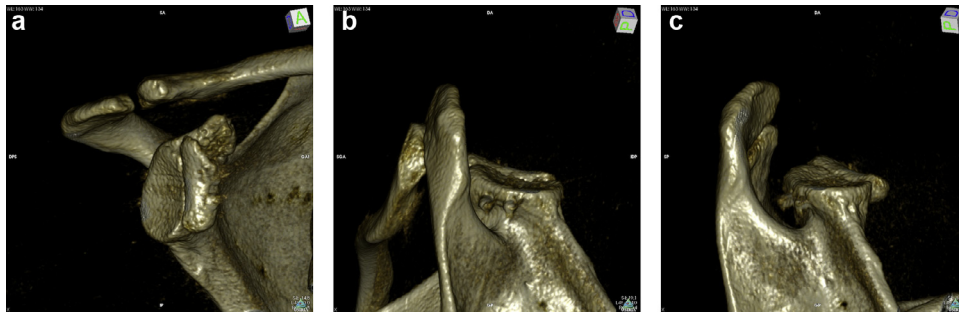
a–c: postoperative 3D CT reconstruction. Anatomic glenoid restored by congruent-arc bone-block, even if the block is slightly too high.
